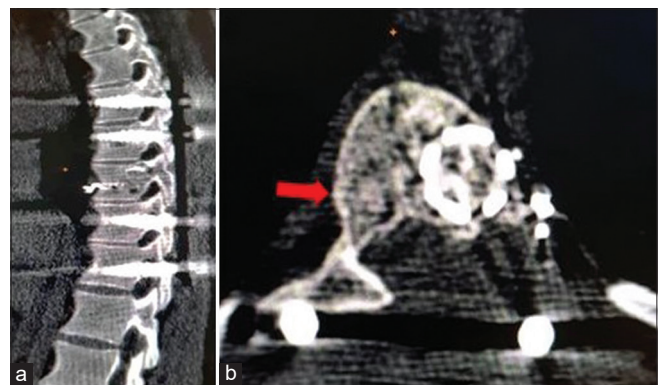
Computed tomography of the spine at end of 2 years. (a) Sagittal section showing complete bone T9 vertebra with intact stabilization and no signs of bony lysis. (b) Axial section showing peripheral sclerotic bone rim formation right side (marked with arrow) and bone formation inside the aneurysmal bone cysts mass.
